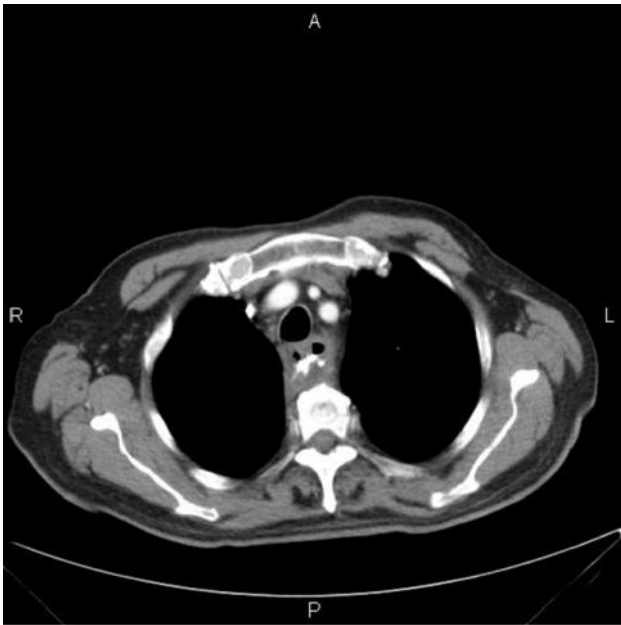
Post procedure CT
